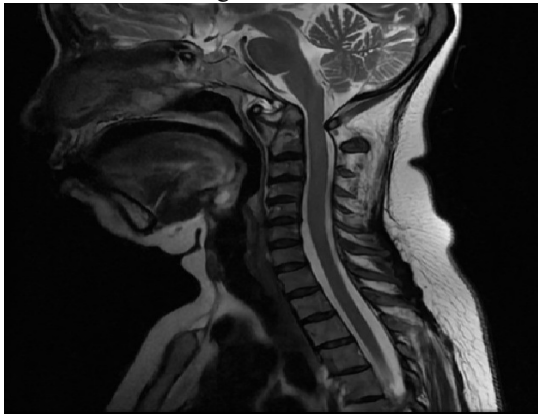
Sagittal MRI of the cervical spine showing atlantoaxial subluxation.
